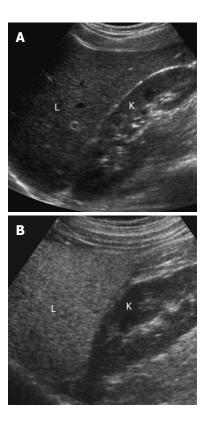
Ultrasonography evaluation of hepatic steatosis. A: Ultrasonography (US) image of a normal liver, showing that the echogenicity of liver parenchyma (L) and kidney cortex (K) is similar; B: US image of a steatotic liver, showing increased echogenicity of the liver parenchyma (L) which is clearly brighter than the kidney cortex (K).
